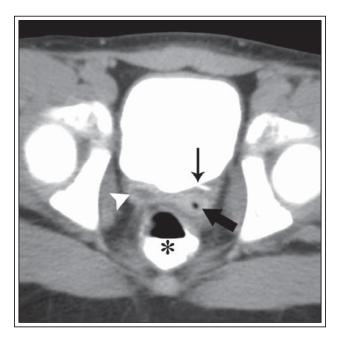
Delayed contrast CT demonstrating fluid filled vagina. White arrowhead points to fluid filled vagina. Thick black arrow points to the left aspect of the vagina containing a small amount of air. Thin black arrow shows normal left ureter inserting into bladder. Asterisk shows enteric contrast in rectum.
